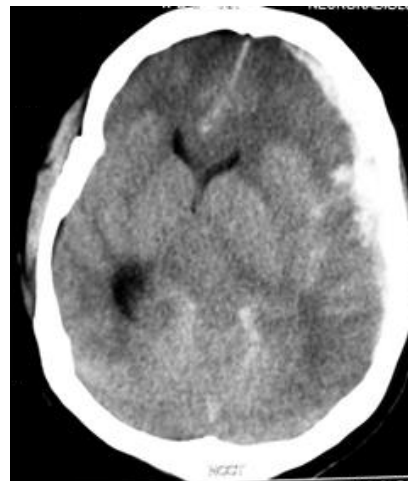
Non-contrast CT scan of head showing left fronto-temporal acute subdural hematoma with midline shift, and fracture of right temporal.
